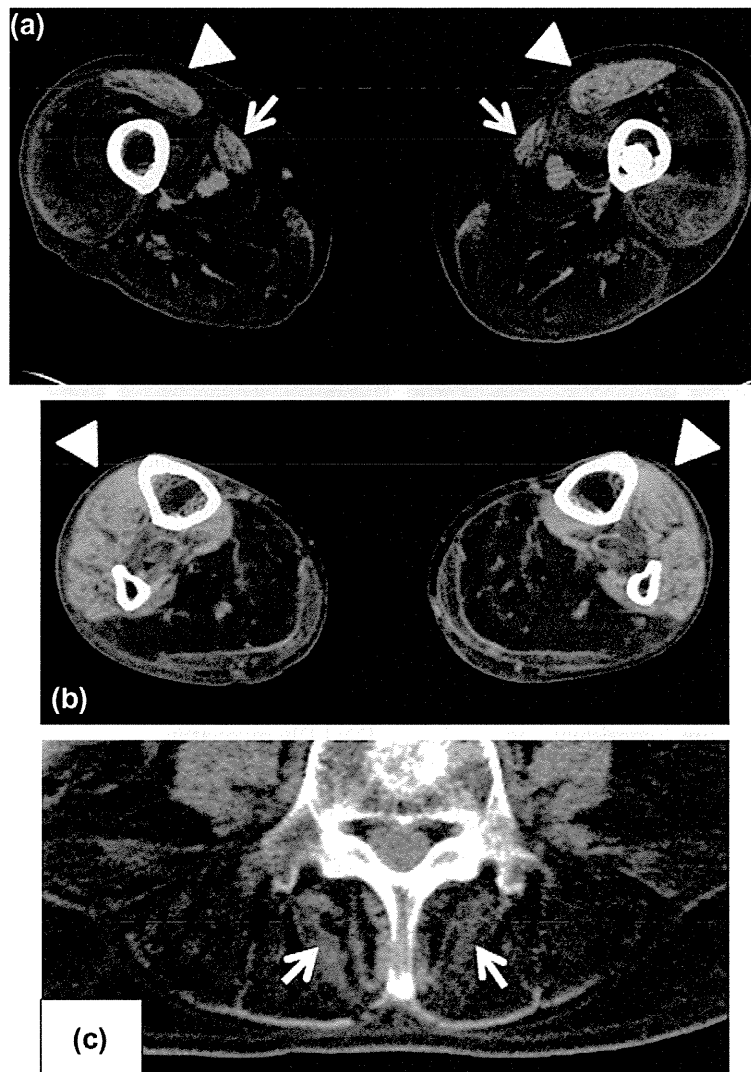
Muscle images of FD-2. Computed tomography analyses of the thigh (a), lower leg muscles (b) and paraspinal muscles at the lumbar level (c). The rectus femoris (arrowheads) and sartorius muscles (arrows) are relatively well preserved (a). Anterior calf muscles are relatively preserved (arrow heads), compared to posterior side (b). The paraspinal muscles are affected, especially in the outer region, whereas their inner regions are well preserved (c, arrows).
